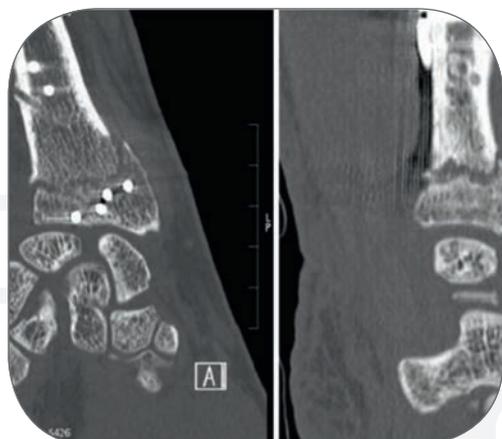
CT scan 7½ weeks post-op showing distal radius non-union
